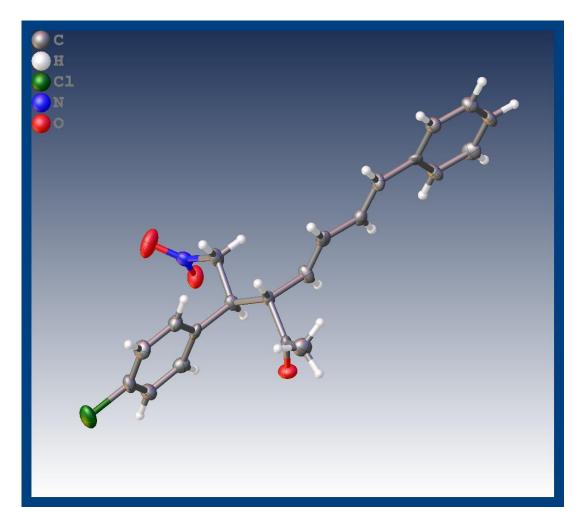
X-Ray image for compound 32Ak.
